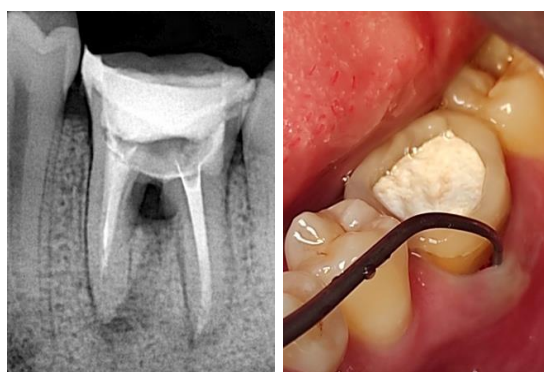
A radiograph of the tooth prior to endodontic retreatment and the clinical condition of the tooth prior to endodontic retreatment.
